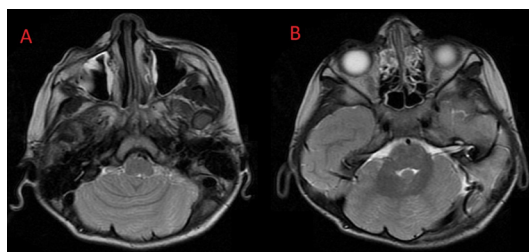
Axial T2-weighted images through the posterior fossa demonstrate fusion of the cerebellar hemispheres, with transversely oriented inferior cerebellar folia (panel A). The caudal cerebellar vermis is deficient (panel B). Note the abnormally shaped 4th ventricle which assumes a 'key hole' shape (panel B). The radiological features are consistent with rhomboencephalosynapsis.
